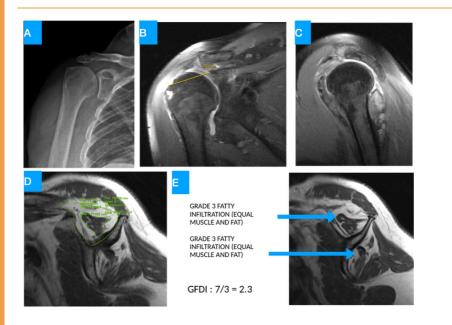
(A)plain radiograph shows decreased acromiohumeral distance ; (B & C) MRI coronal and sagittal sections show posterosuperior cuff tear ; (D) Occupancy ratio calculation by Thomazieu et.al method ; (E) Fatty infiltration calculated by Goutallier et.al method.
